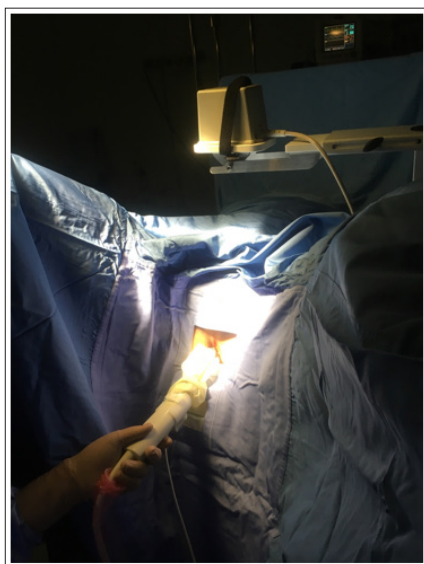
Ultrasound-Guided Local Transperineal Anaesthesia
